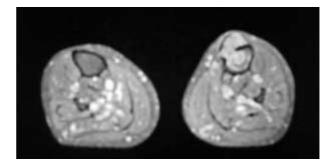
On the T2-weighted image, small bright-signal areas were sometimes seen in the lesion, which corresponded to cysts filled with blood. After contrast administration, the hypointense solid mass lesion on T1-weighted image showed enhancement. Most areas of lesions became brighter focally with unstained dark areas on enhanced fat suppressed T1-weighted images.
